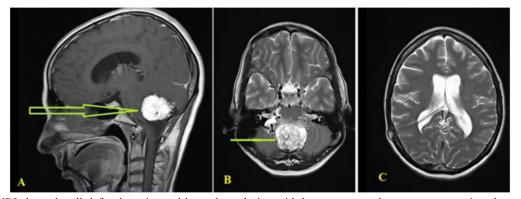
Brain MRI showed well defined semi-round hyperdense lesion with homogenous enhancement measuring about $(3.5 \times 3 \times 3.5 \text{ cm})$ mass occupying the fourth ventricle and casing mild hydrocephalous and diffuse brain edema associated with periventricular ischemia change, which was highly suspected to be a posterior cranial fossa tumor.
